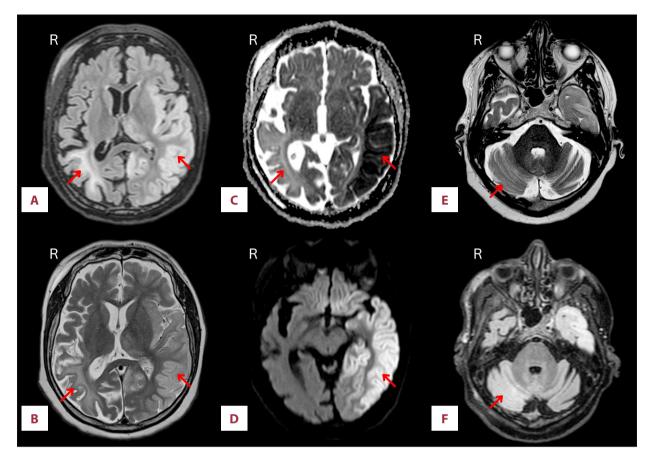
First axial magnetic resonance image. (A) FLAIR-weighted and (B) T2-weighted showing vasogenic edema throughout the left cerebral hemisphere including the temporal, occipital lobes, thalamus and hippocampus. On the right side an older deep peri-ictal lesion with atrophy from a previous seizure. (C) Diffusion-weighted apparent diffusion coefficient (ADC) and (D) diffusion weighted imaging (DWI) showing a decrease in ADC value and increased DWI signal throughout the left cerebral hemisphere and a slightly increased ADC value in the right cerebral hemisphere. As well as (E) T2-weighted and (F) FLAIR-weighted of cerebellum showing a small area of vasogenic edema in the right cerebellum, cortically affecting the amygdala as well, on the opposite side of the cerebral lesion – a crossed cerebellar diaschisis.
